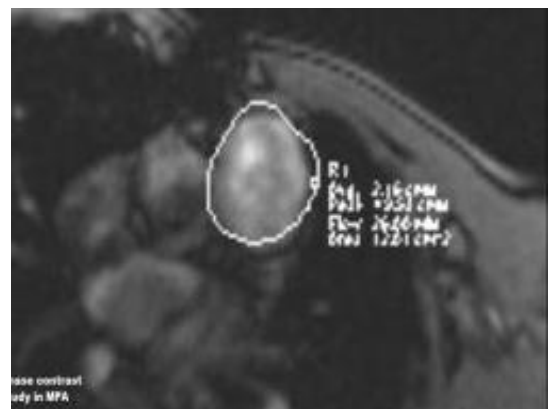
Cardiac MRI RVOT view shows pulmonary phase contrast study.
